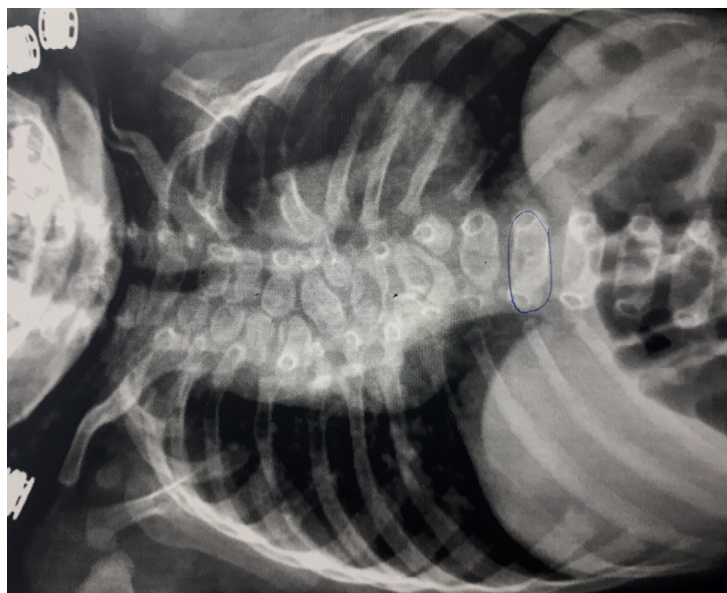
Radiograph showing congenital multiple malformed vertebral at thoracic level Th3 to Th8
